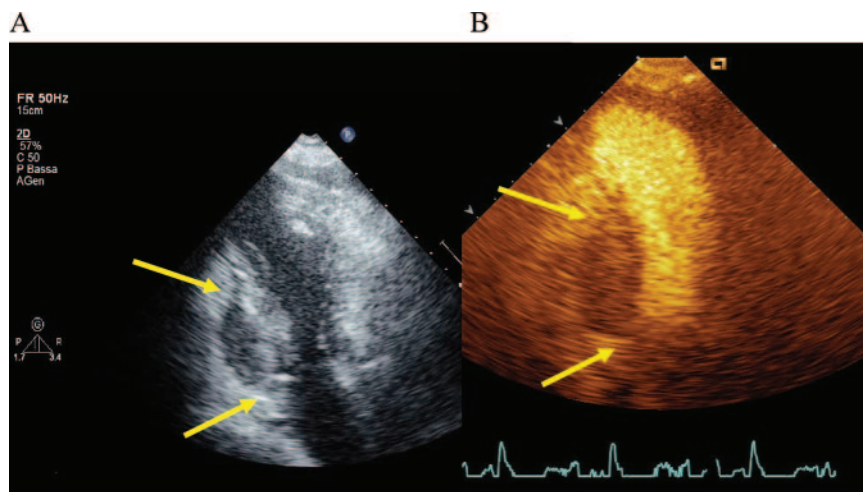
Two-dimensional (A) and myocardial contrast echocardiography (B) images in 2-chamber view. An expansive lesion of the basal segment of the inferior wall is evident in both images between arrows. A, The lesion appears to be of reduced echodensity with tissue characteristics intermediate between blood and tissue. B, The lesion appears darker than normal adjacent myocardium and thus significantly hypoperfused.
